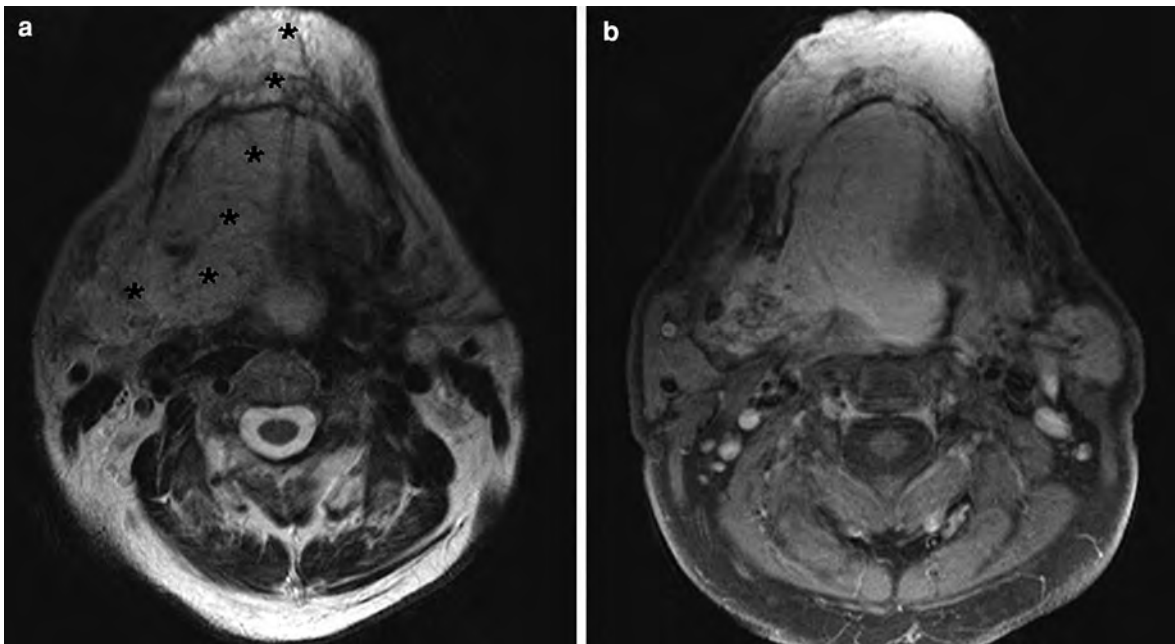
MRI of a venous malformation with hardly any flow-voids in a 65-year-old male. The lesion shows diffuse extension through the mandible and the mylohyoid muscle into the lower lip and the submandibular region. Moreover, there is midline
